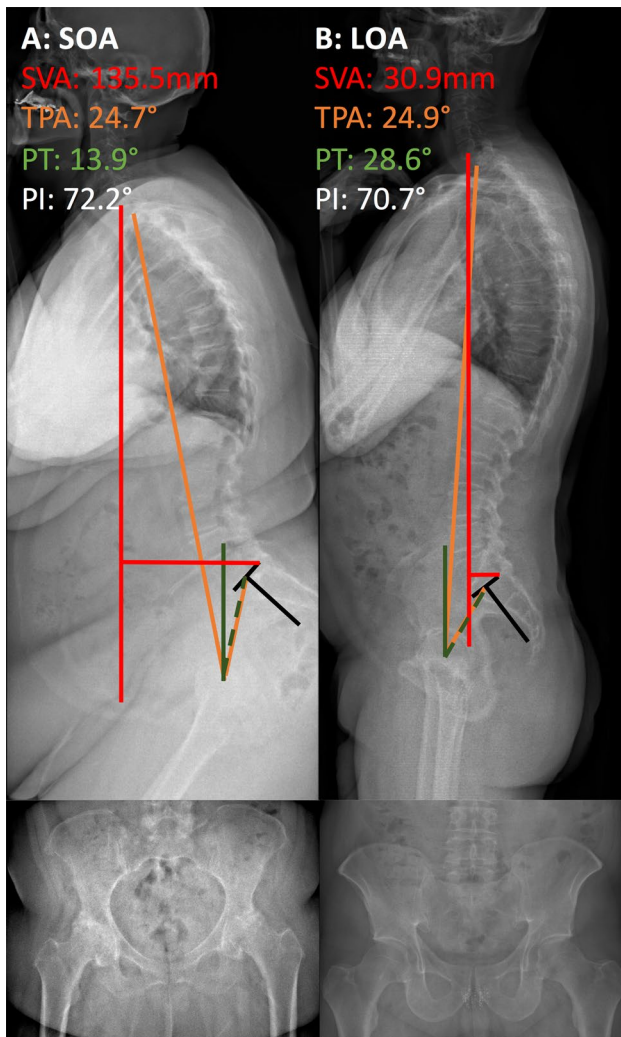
Radiographs of two patient with similar Pelvic Incidence (PI) and spinopelvic deformity as measured by T1-Pelvic Angle (TPA). Note the higher Sagittal Vertical Axis (SVA) and low pelvic tilt (PT) in the patient with Severe hip OA (SOA-left) when compared to the patient with low grade hip OA (LOA)
